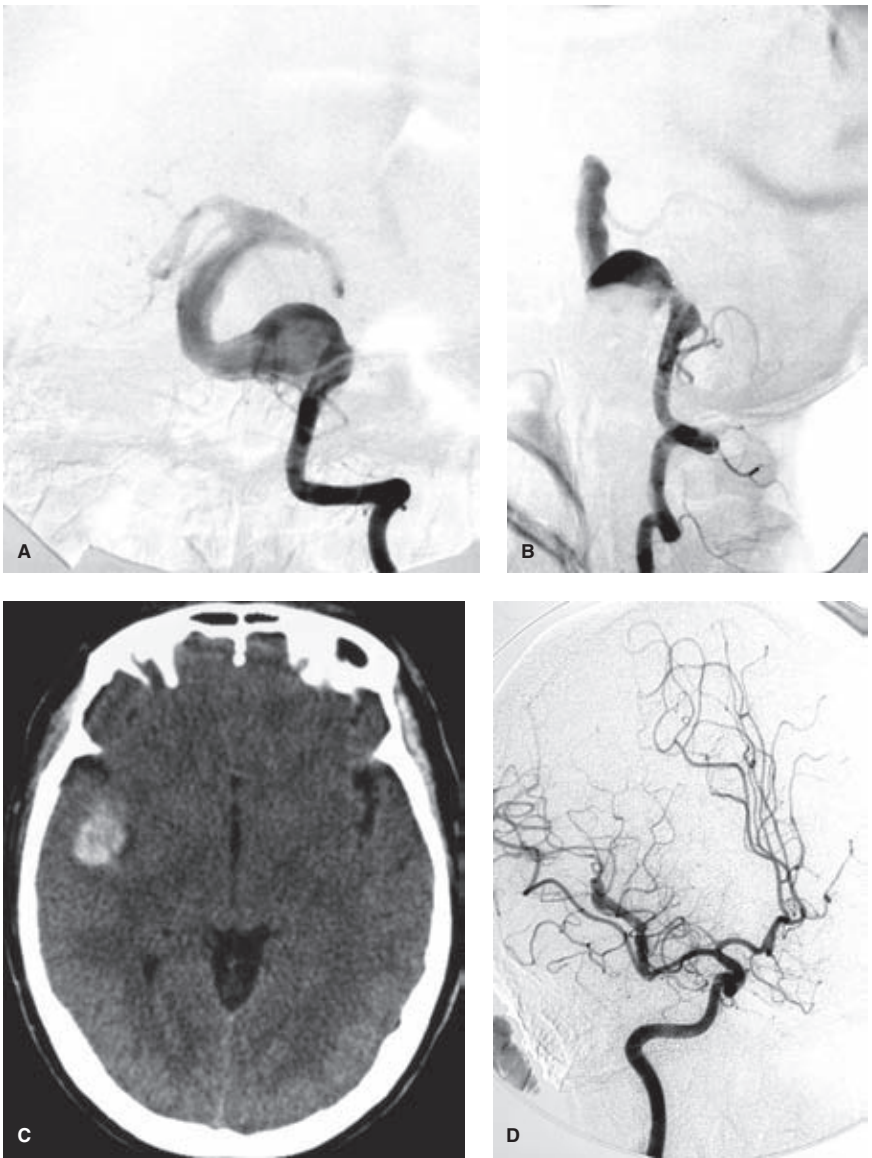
(A–D) Megadolichoectatic basilar artery and serpentine aneurysm. (Two cases) Townes (A) and lateral (B) projections of a megadolichoectatic basilar artery in an elderly hypertensive patient. A CT scan of the head (C) in a young adult presenting with sudden headache demonstrates a focal collection of blood in the right Sylvian fissure. An oblique RAO view (D) of the right internal carotid artery injection demonstrates an elongated fusiform or “serpentine” aneurysm of the parietal branch of the right middle cerebral artery.
